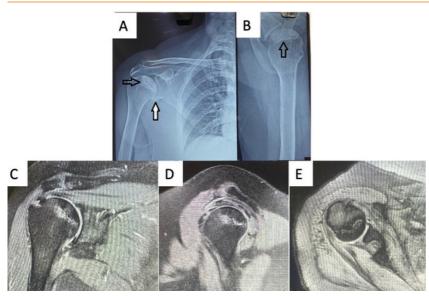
Pre-operative imaging: A, B: Plain radiographs with wedge shaped sclerotic lesion suggesting AVN (black arrow) with glenoidal inferior osteophyte (white arrow), C,D,E: MRI (a- coronal b-sagittal c-axial) sections showing small supraspinatus tear with upper subscapularis tear with sclerotic lesion without subchondral collapse (Cruess stage 2 AVN).
